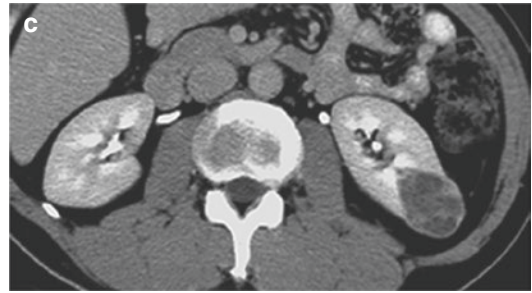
Multiphase CT study demonstrates precontrast (a), arterial phase (b) and nephrogenic phase (c) axial images of a well-circumscribed, exophytic renal cortical mass in the posterior left kidney. Septations seen on
